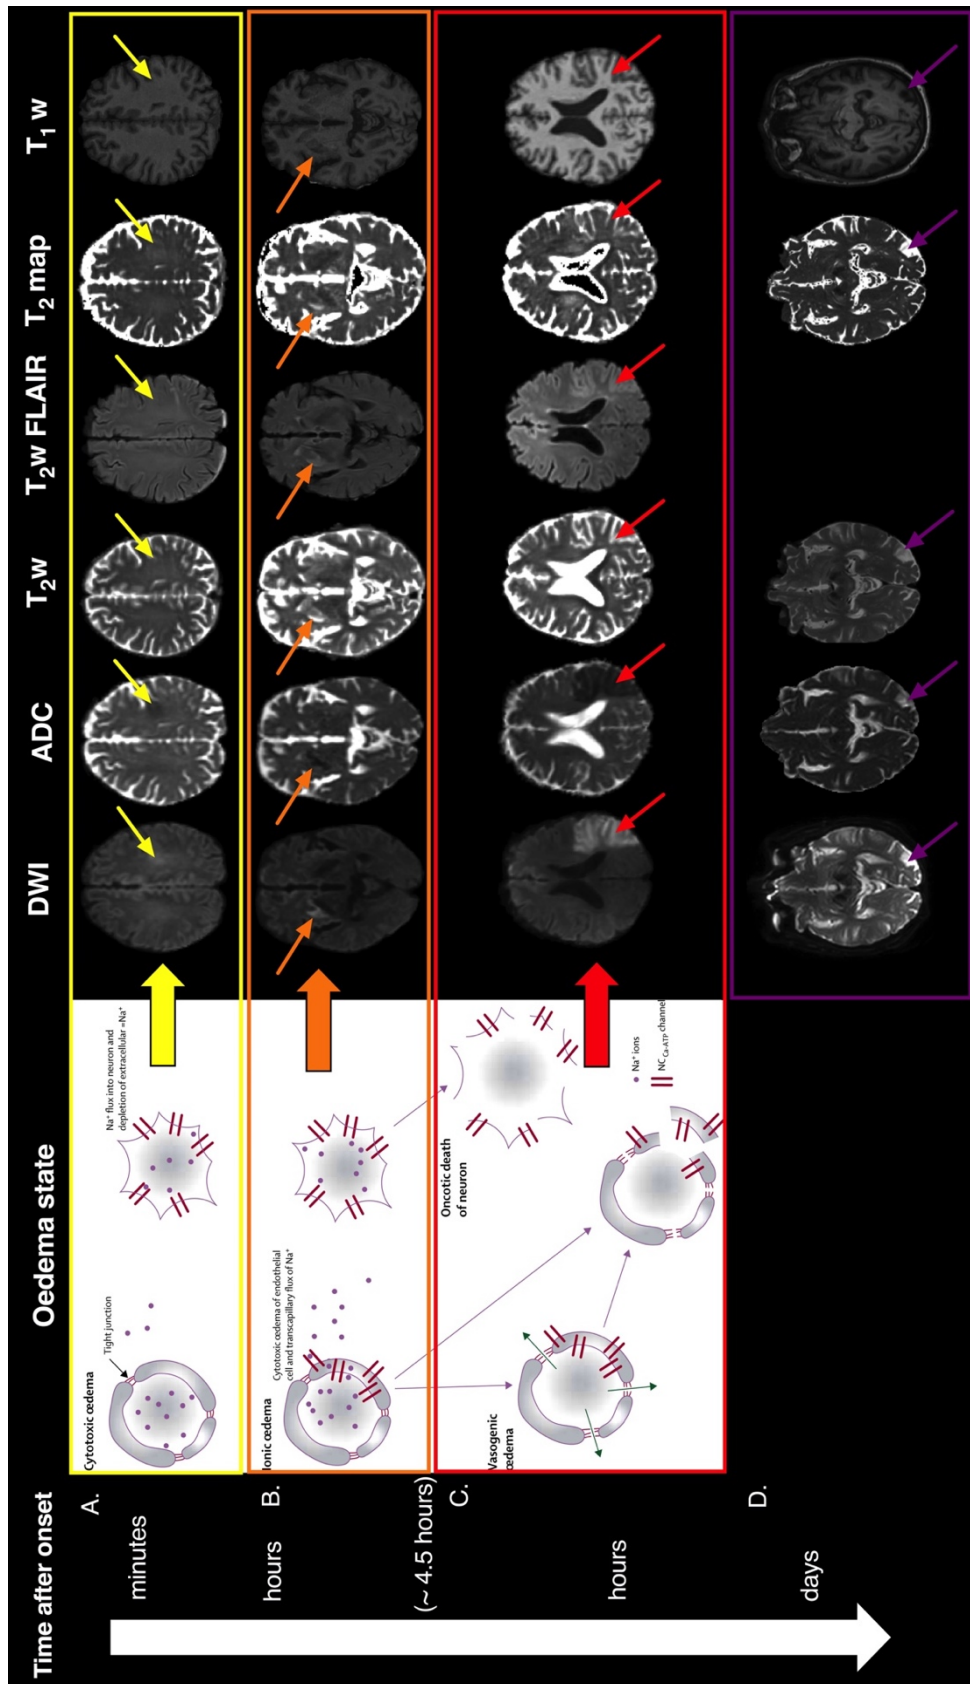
Summary of oedema progression during ischaemia in relation to MR images. The oedema section is the same figure shown in Chapter 2 and is reproduced from Simard et al. (2007) with permissions. 4.5 hours is written in brackets as it is an approximation as it is difficult to give precise timings of the visibility and onset of vasogenic oedema.
